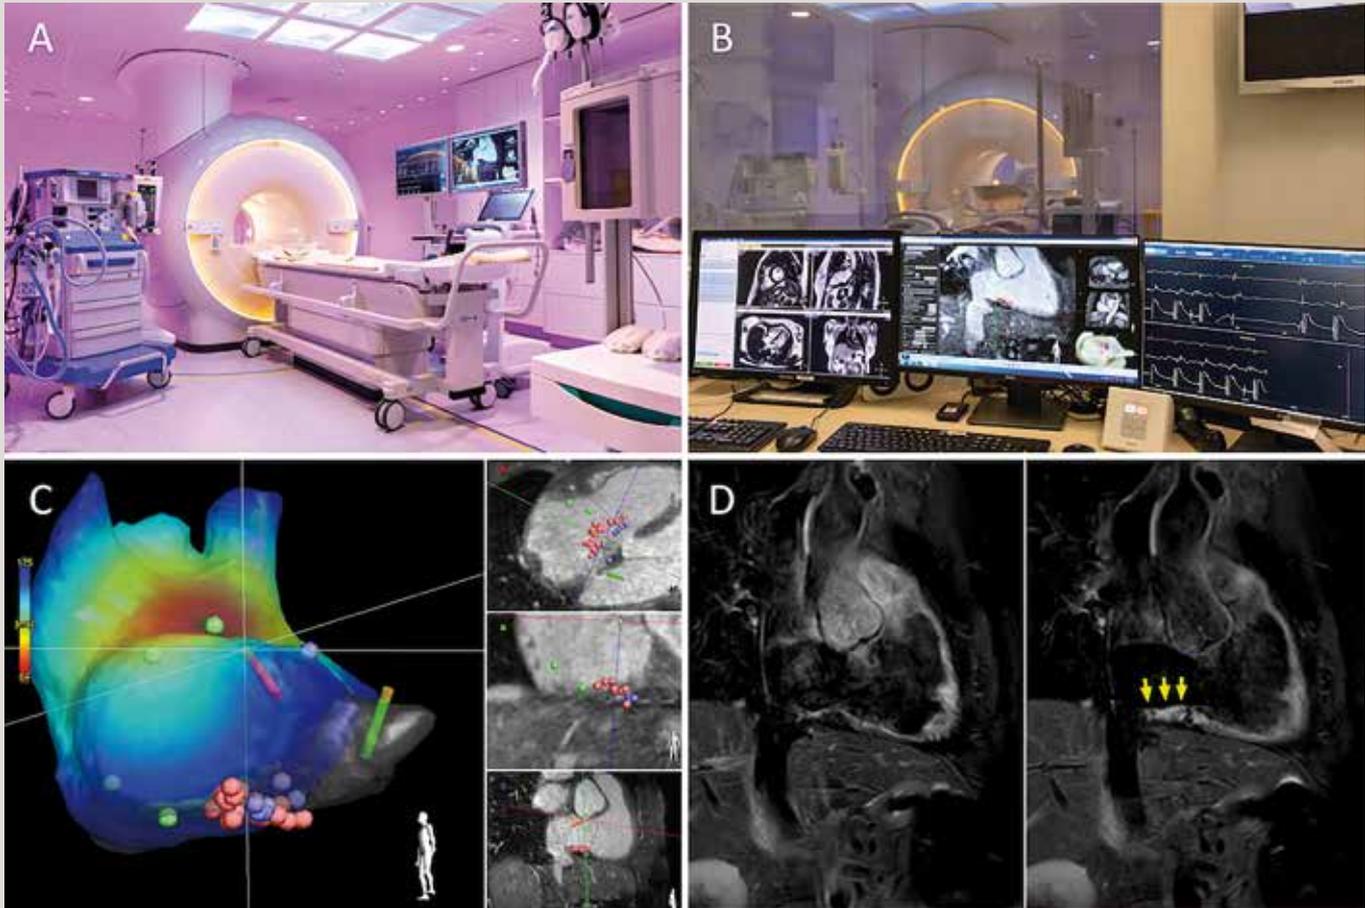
Transformation of an existing radiology space into an iCMR suite (A) and control room (B). During the procedure, an electrical colour map of the right atria, including the ablation points, can be projected onto the high-resolution CMR model to confirm the desired bidirectional electrical block (C). Immediately after ablation, T2-weighted MR imaging (D) can be performed to visualise oedema near the ablation area (right, yellow arrows) and compare it with the pre-ablation oedema imaging (left).
